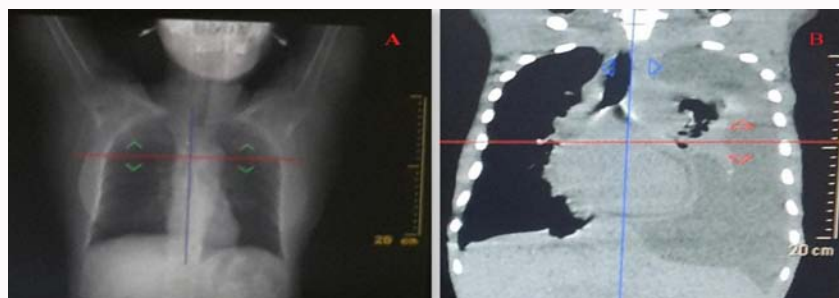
(A) Shows normal chest X-ray, (B) shows central type neoplastic lesion with pleural effusion.
